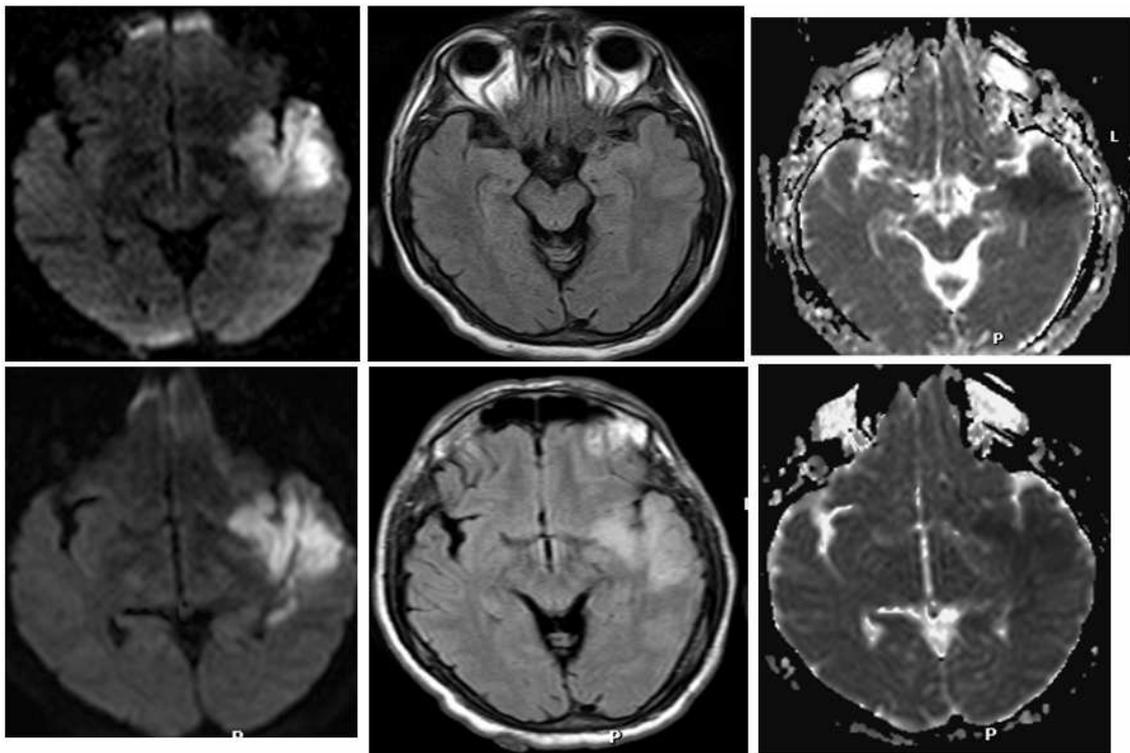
Ischemic lesion in DWI (left) and ADC map.
